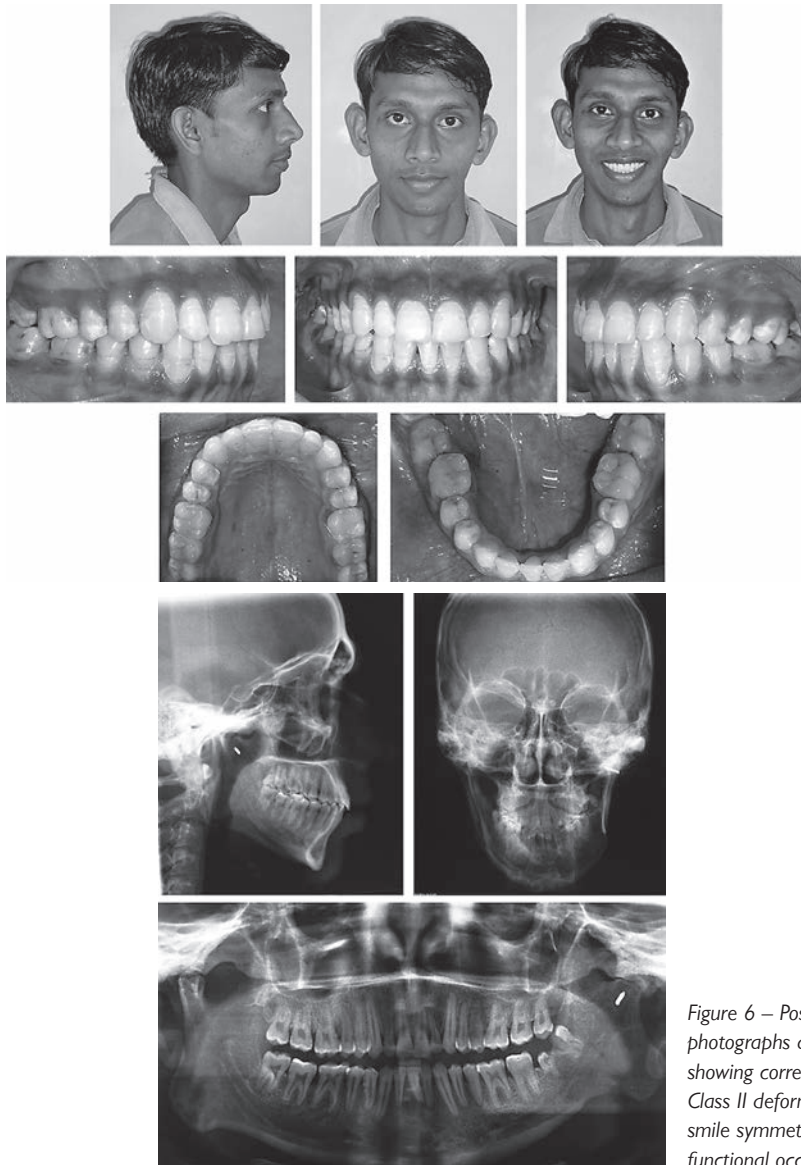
Posttreatment photographs and radiographs showing corrected asymmetric Class II deformity with restored smile symmetry and Class I functional occlusion.
